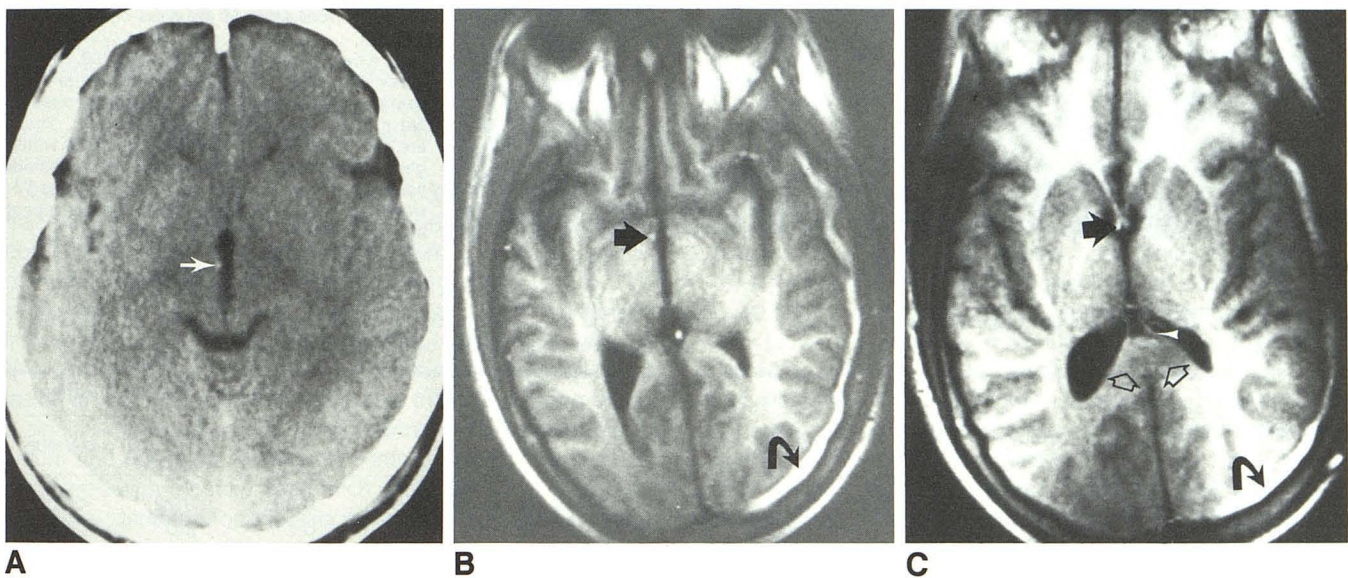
A, Axial CT scan appears normal except for small hemorrhagic lesion of anterior column of fornix (*arrow*). B and C, Axial T1-weighted IR images, 2000/600, confirm hemorrhagic lesion in fornix (*straight solid arrows*). This small 9-day-old hematoma is hyperintense on T1-weighted images because of methemoglobin within lesion. An extensive, nonhemorrhagic lesion is also present bilaterally within splenium of corpus callosum (*open arrows*). Associated with callosal lesion is traumatic disruption of crus of fornix (*arrowhead*) near its junction with corpus callosum. A small subacute subdural hematoma is also noted (*curved arrows*).
